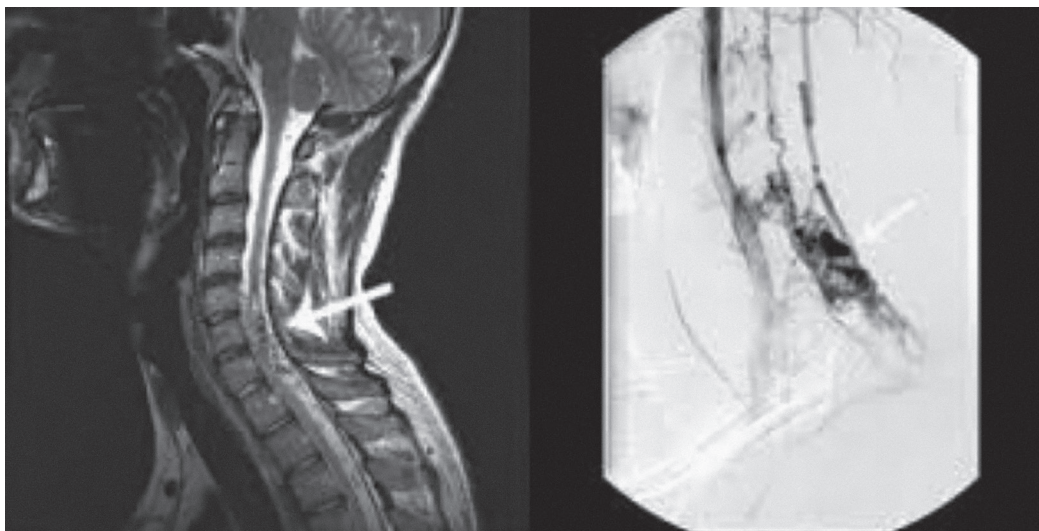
Cervical AVM. Left: MRI demonstrating (arrow) a spinal arteriovenous malformation (AVM) with its classical “bag of worms” appearance. Right: Spinal angiography demonstrating the anatomical characteristics of the AVM.
